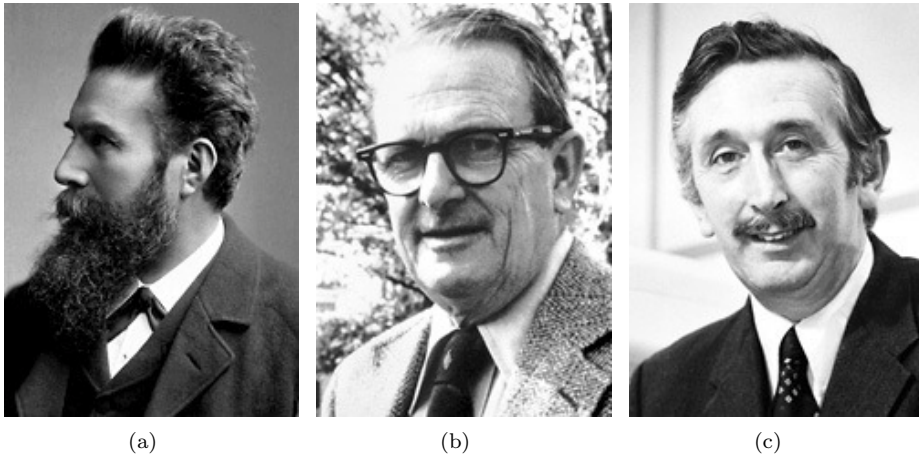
Three Nobel prize winners who played a role in the history of computed tomography. (a) W. C. Röntgen, (b) A. M. Cormack, (c) G. N. Hounsfield. Photographs © The Nobel Foundation.
